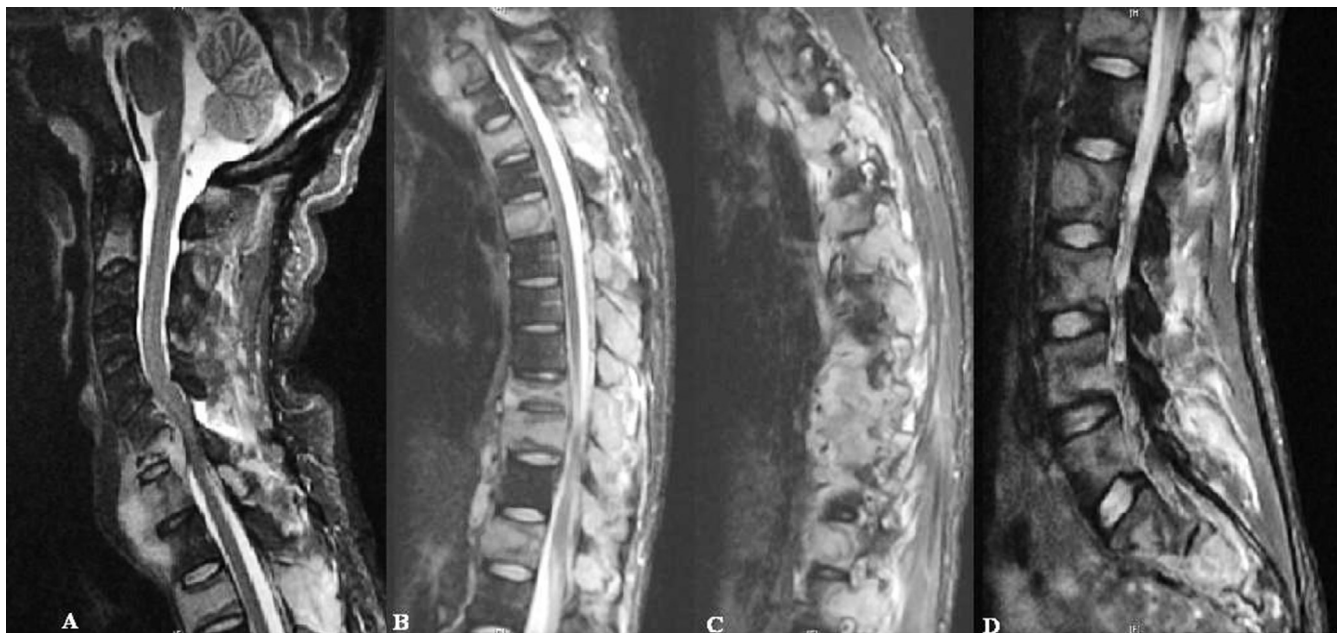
Cervical (A), thoracic (B and C), and lumbar (C) T2-weighted MRIs demonstrating extensive disease at essentially all spinal levels. Note the large C7 lesion resulting in severe epidural compression in panel A.
